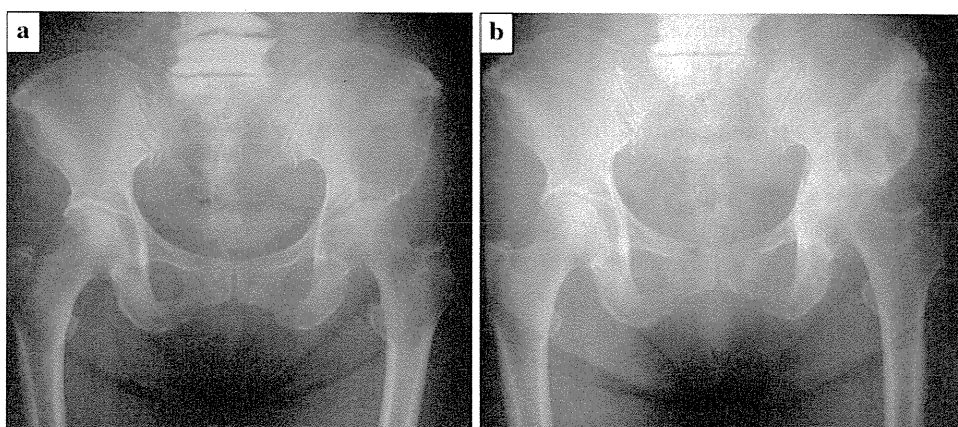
Case 2. a Plain film shows the osteolytic lesion of bone metastases in the left ilium. b Plain film shows the prominent sclerotic change after local radiation therapy
